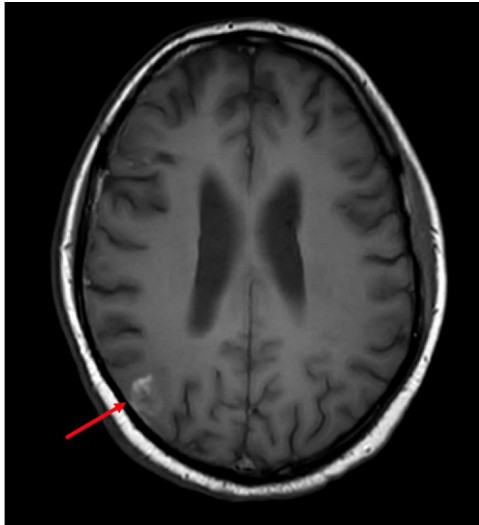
An axial section of a T1 weighted MRI of the brain reveals a T1 hyperintense lesion in the right parietal lobe (red arrow).
